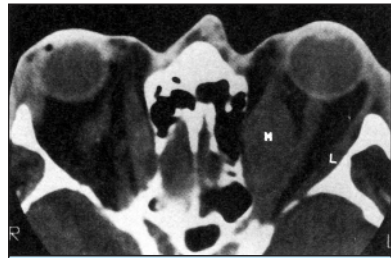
CT scan of thyroid orbitopathy showing fluid infiltration of the medial rectus muscle (M) and normal lateral rectus muscle (L) and proptosis. Compression of left optic nerve could cause optic neuropathy. This is called *crowded apex syndrome*. Source: Courtesy of Jack Rootman.
